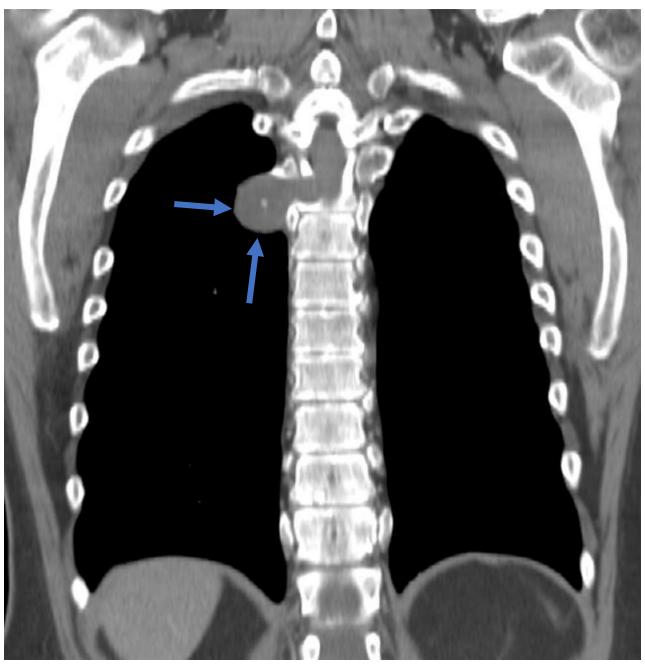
Coronal CT scan. Soft tissue lesion (blue arrows) originating from the posterior spine region and forming a smooth interface with the lung. Note the presence of central calcification. This corresponds with the PA chest X-ray finding.
